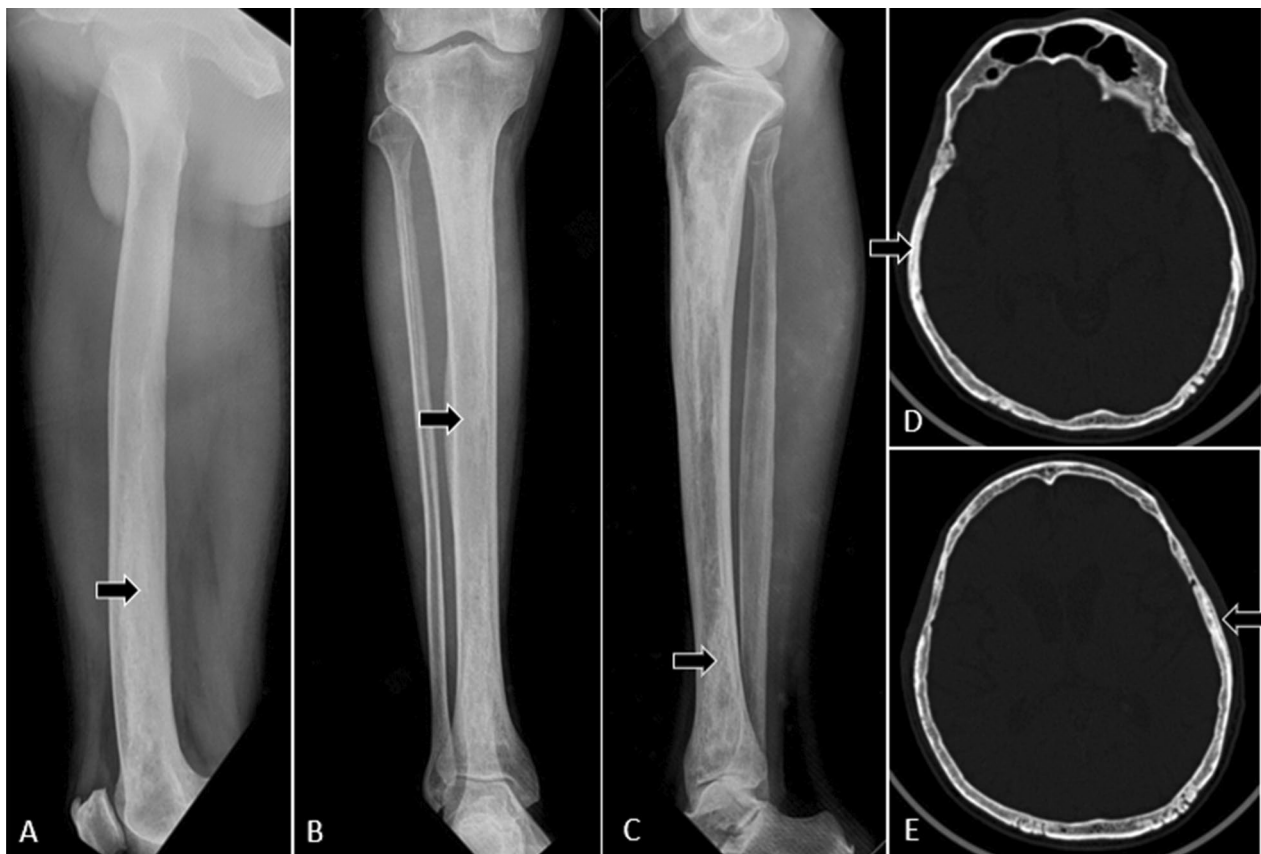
Radiographs of a 60-year-old male patient diagnosed with Erdheim–Chester disease reveals regions of diffuse sclerosis with loss of cortico-medullary differentiation in diaphysis and metaphysis of right femur (A, B) and tibia (C) with bone within bone appearance. Computed tomography of the brain reveals ill-defined areas of sclerosis in the calvarium (D, E)
